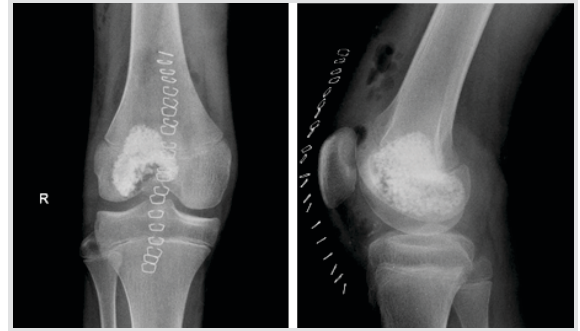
(a and b) Immediate post-operative X-ray showing entire removal of lesion and the cavity filled with bone graft.
